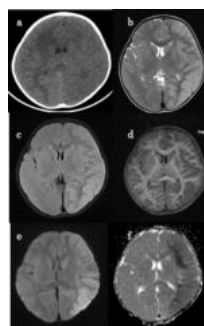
NCCT brain showing loss of grey white matter differentiation along with effacement of sulci in left cerebral hemisphere (a). MRI Brain showing hyperintensity along the cortex in left cerebral hemisphere along with gyral swelling and effacement of sulci in left cerebral hemisphere on T2WI (b) , FLAIR axial images (c), T1 weighted images (d) with diffusion restriction on diffusion weighted images (e & f)
